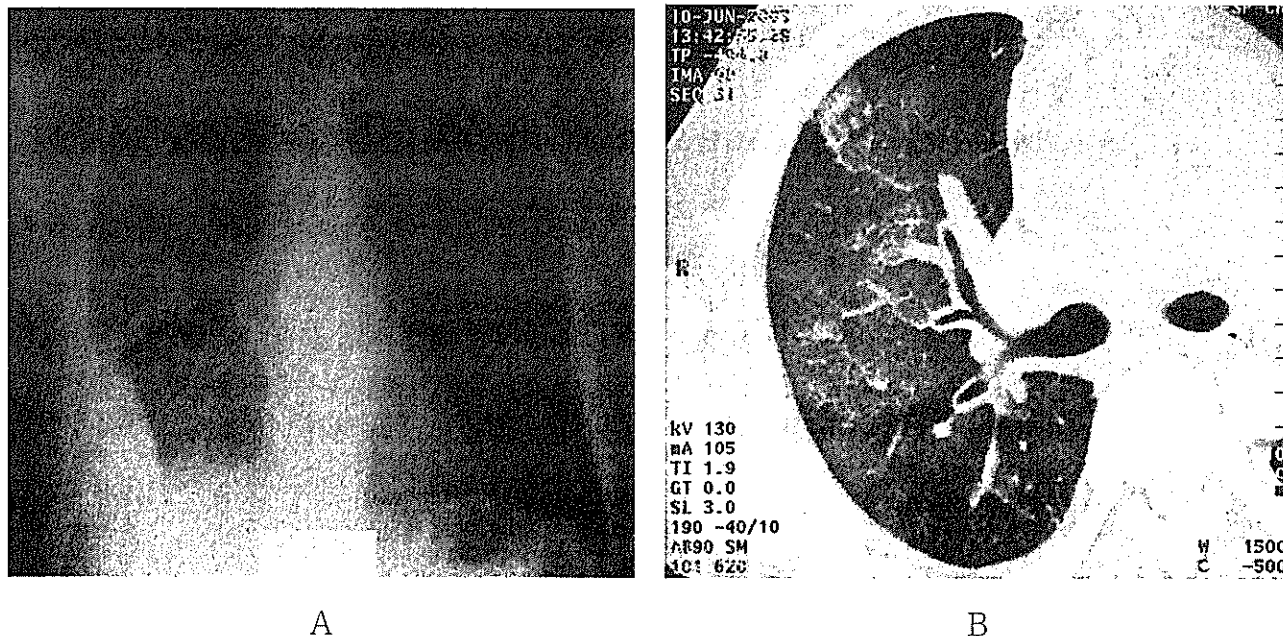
Chest radiograph (A) and CT scan (B) showing ground glass opacity in the right middle to lower fields.
